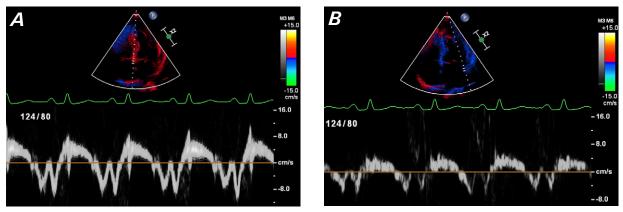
Transthoracic Doppler echocardiogram shows the A) septal and B) lateral mitral annulus. Because of lateral wall tethering, the lateral e' velocity is reduced in comparison with the septal e' velocity (annulus reversus).
